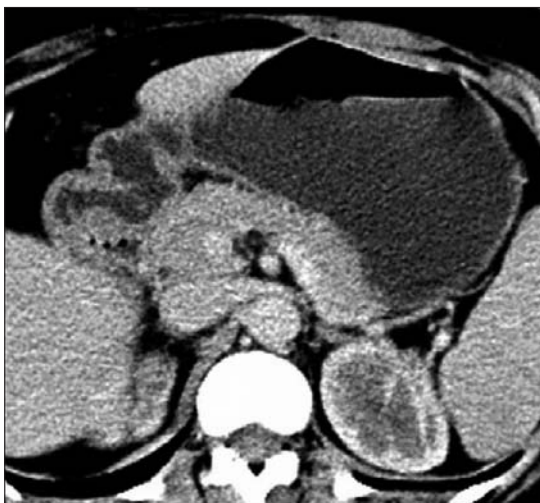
Contrast-enhanced abdominal CT image of a 33-year-old woman with hydatid cyst of the liver, shows a non-contrast enhancing focal mass-like lesion of 15–19 mm, located on the posterior wall of the grade 1 distended antrum and relative thickening of the antrum compared with gastric body. Endoscopic examination did not demonstrate any mass lesion, and *H. pylori* test was negative.
